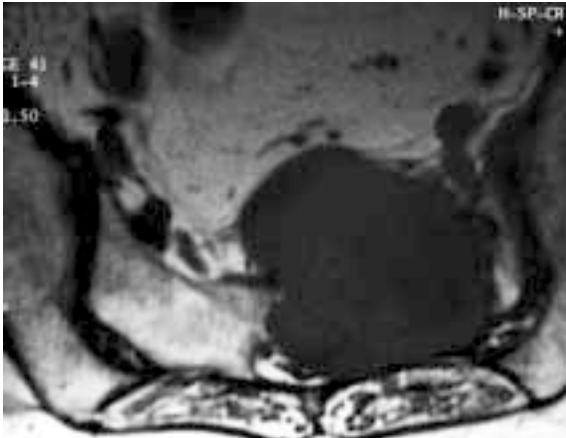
Axial T1-weighted MR image of a 78-year-old Caucasian woman suffering from two years of back pain. A 7 cm diameter well-defined homogeneously hypointense lesion is seen arising from the sacral canal and left S3 body. A greater portion of the tumour occupies the sacrum and only a proportionately smaller component extends anteriorly to the presacral space.
